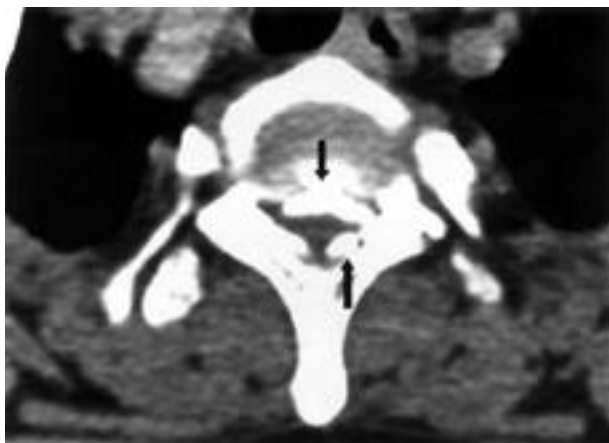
The preoperative CT scan reveal ossification of posterior longitudinal ligament and ligamentum flavum at T1-2 level (case 3).
